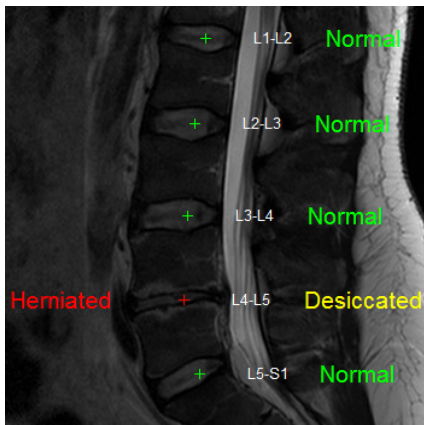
LumbarCAD results projected on a Mid-Sagittal clinical MRI.
